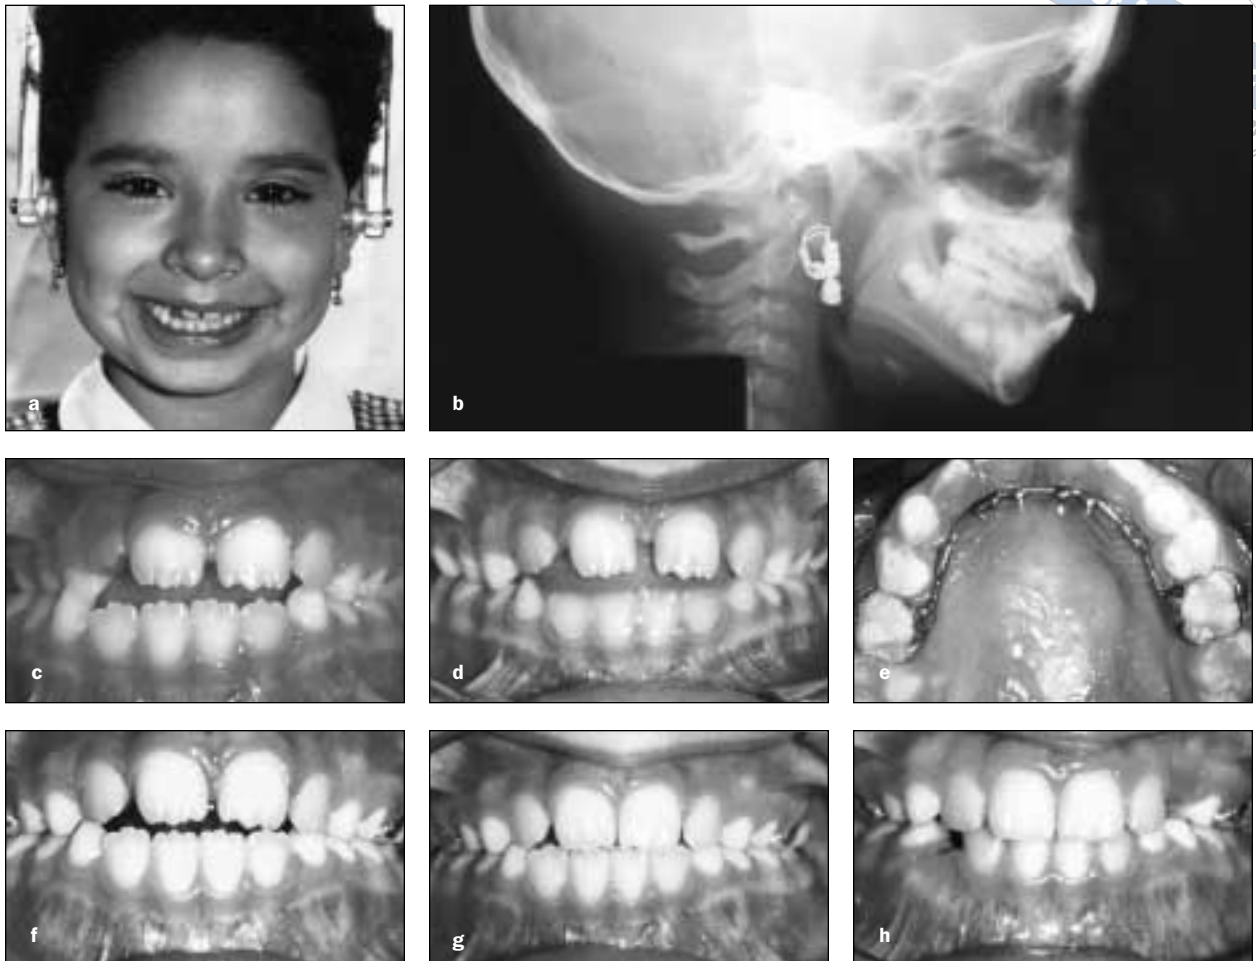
Patient B. The patient is a girl, 8 years 1 month of age. (a) Initial facial photograph. (b) Initial radiograph, which demonstrates the anterior open bite. (c) Initial intraoral photograph. Note the anterior open bite and posterior right crossbite. (d) Post-rapid maxillary expansion intraoral photograph taken 3 months after the start of treatment. There has been no improvement in the anterior open bite. (e) Intraoral photograph taken at spur appliance cementation. Patient is 8 years 4 months of age. (f to h) Intraoral photographs taken at 8 years 4 months, at 8 years 7 months, and at 9 years 9 months of age. The appliance was removed when the patient was 9 years 9 months of age, 6 months after the anterior open bite had closed. (i,j) Posttreatment facial photograph and radiograph taken at 13 years 10 months of age. A pleasing upper-lip smile line and a positive overbite with incisal contact were established. (k to n) Photographs and radiograph taken at 26 years 11 months of age, 17 years posttreatment without retention. Note the stability of the corrected anterior open bite and the posterior crossbite. A positive overbite without incisal contact is evident. (o) Superimposition of radiographic tracings at 8 years 1 month of age, 13 years 10 months of age, and 26 years 11 months of age. A vertical growth pattern is demonstrated.
